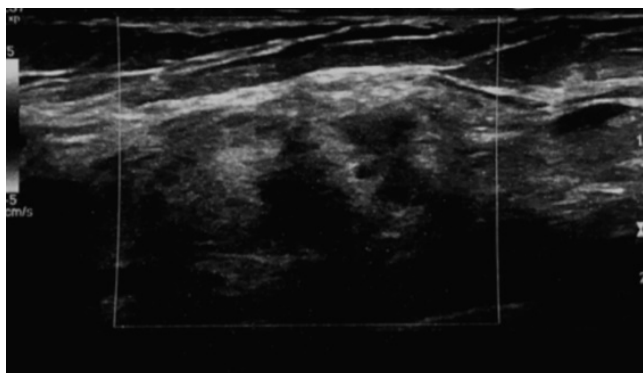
Ultrasonography showing an oval nodule, parallel to the skin, circumscribed, heterogeneous, without flow to the color Doppler study, at the union of the lateral quadrants, at 9 am, 4 cm apart from the papilla, measuring 2 × 1.4 × 1.8 cm.
